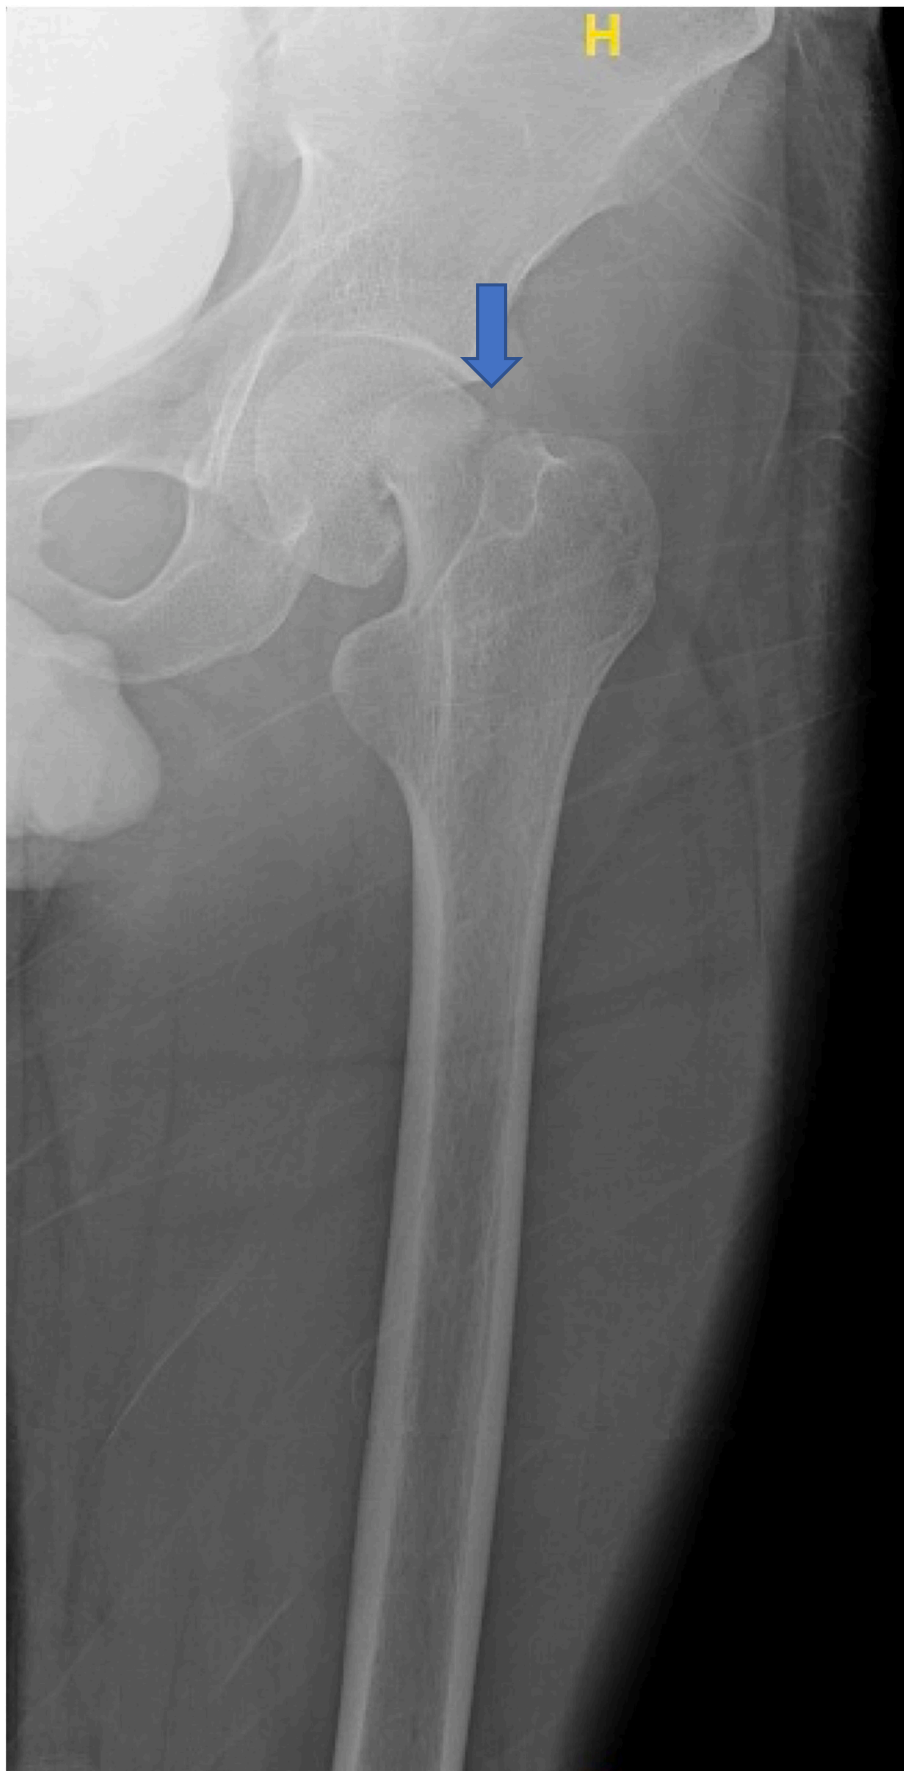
Left femur X-Ray demonstrating the right femoral neck fracture. The arrow is marking the fracture.
